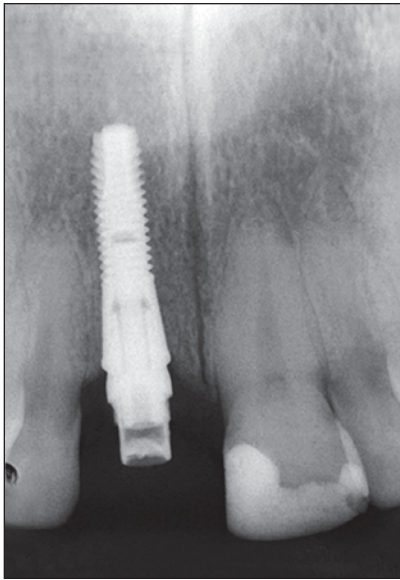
Radiographic evaluation of implant at 3 weeks following placement revealed modest depth of placement and selection of a 1.0-mm abutment for provisional restoration. Clinical implant depth of placement was coincident with the buccal crest of bone.
